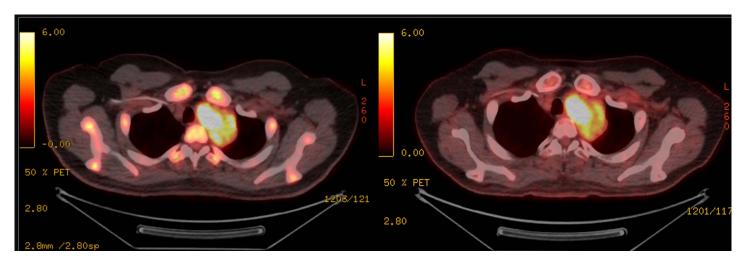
Initial PET-CT (left) showing FDG-avid mass in upper mediastinum measuring 7.6×5.2 cm with SUV of 10.7. Diffusely increased activity noted in the skeleton and bilateral kidneys with FDG-avid mediastinal and abdominal lymphadenopathy. After four cycles of cytotoxic chemotherapy, restaging scan (right) showed interval resolution in kidneys, skeleton, and abdominal lymph nodes, but mediastinal mass persisted with stable size and increased SUV. FDG: fluorodeoxyglucose; PET-CT, positron emission tomography–computed tomography; SUV: standardized uptake value.
